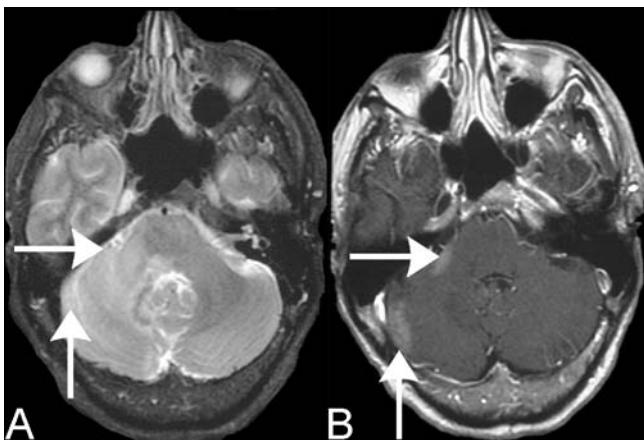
Axial brain MR images. a T2-weighted image shows increased signal in the right pons, brachium pontis, and cerebellum (arrows). b Postcontrast T1-weighted image demonstrates enhancement along the lateral aspect of the signal abnormality (arrows)
